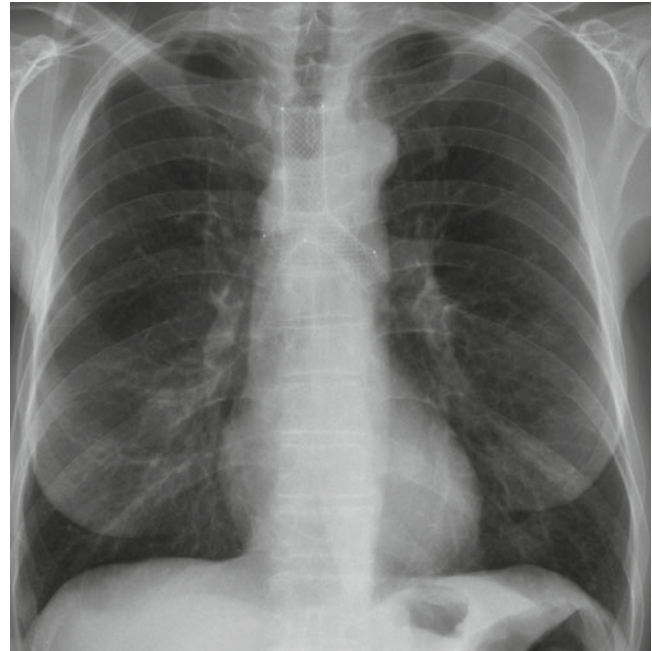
Chest X-ray after implantation of a self-expandable metallic Y-stent
